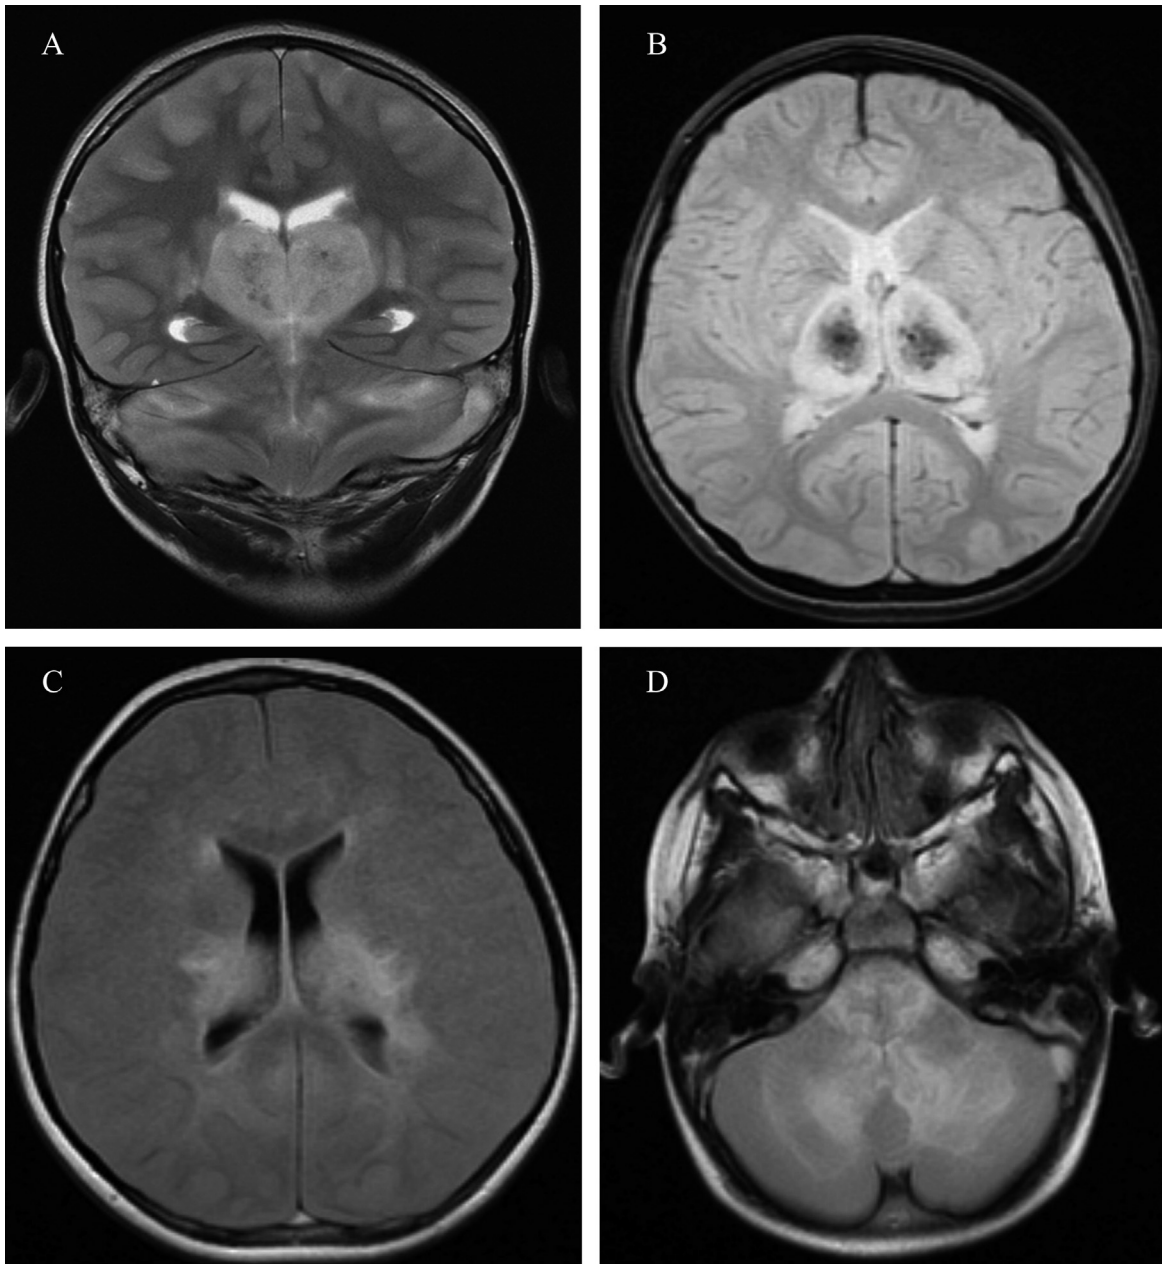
(A) Coronal T2-weighted sequence demonstrates edematous symmetrical swelling of the thalami bilaterally with petechial hypointense necrotic foci within. There is also patchy high T2 signal abnormality affecting the capsular white matter, the cortical mantle and subcortical white matter, and the cerebellar hemispheric parenchyma bilaterally. Early cerebellar tonsillar descent is present. (B) Axial gradient recall echo T2-weighted sequence through the thalami and third ventricle. The hypointense early blooming in the edematous thalami confirms the necrotic hemorrhagic nature of the underlying etiology. (C) Axial fluid attenuated inversion recovery sequence through the level of the bodies of the lateral ventricles demonstrates generalized cerebral swelling and relatively symmetrical abnormal high T2 signal abnormality in the deep white matter with involvement of the periventricular white matter and corona radiata of both cerebral hemispheres. (D) Axial T2-weighted sequence through the posterior fossa at the level of the pontomedullary junction. Abnormal symmetrical T2 signal abnormality is present in the brain stem and the cerebellar hemispheric parenchyma.
